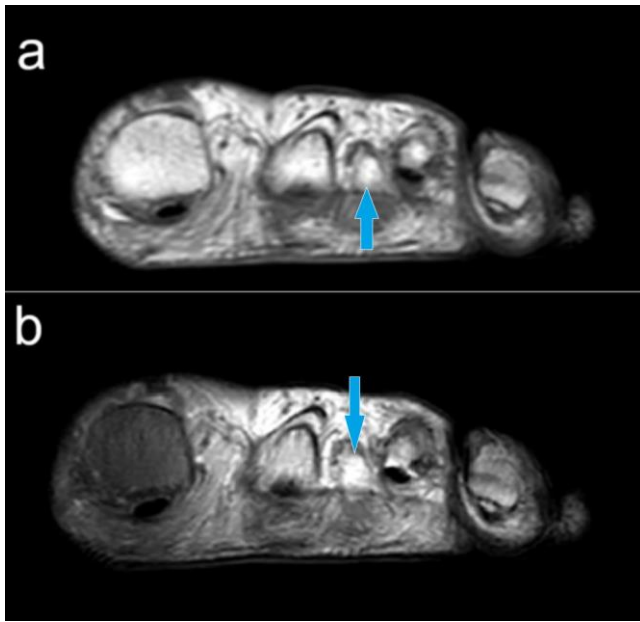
a) T1 MR image, b) T2 MR image of Morton's neuroma located between the 2nd and 3rd metatarsal heads of the patient's foot (arrow).
